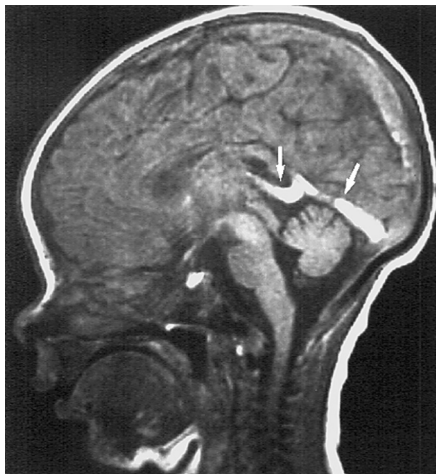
Venous thrombosis is seen as a high signal area on magnetic resonance imaging (MRI; sagittal image). The great vein of Galen and straight sinus are involved (*white arrows*). (From Katz DS, Math KR, Groskin SA. *Radiology secrets*. Philadelphia: Hanley & Belfus, 1998, with permission.)
